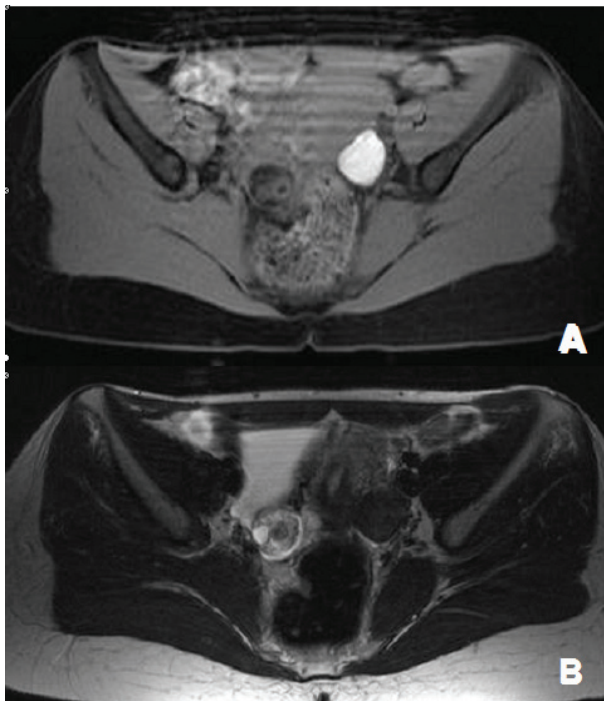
T1-weighted-fat-suppressed image showing a hyperintense mass on the left ovary and a disomogenous hypointense mass on the right one (A). On T2-weighted sequence (B) the left mass appear hypointense. The left mass proved to be an endometrioma with recent hemorrhage; on the contrary, owing to its appearance on fat-suppressed sequence, the right mass proved to be a dermoid cyst.
